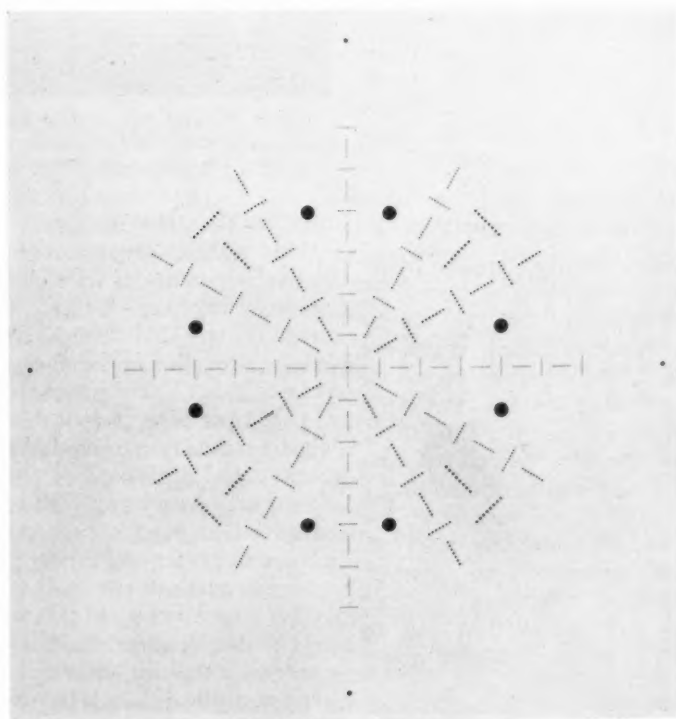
Philips electric brass reticle. The roentgenogram shows the pattern of small holes of varying size. The holes and spaces are equal in width, and the rows running at 90° to one another are of the same caliber.
